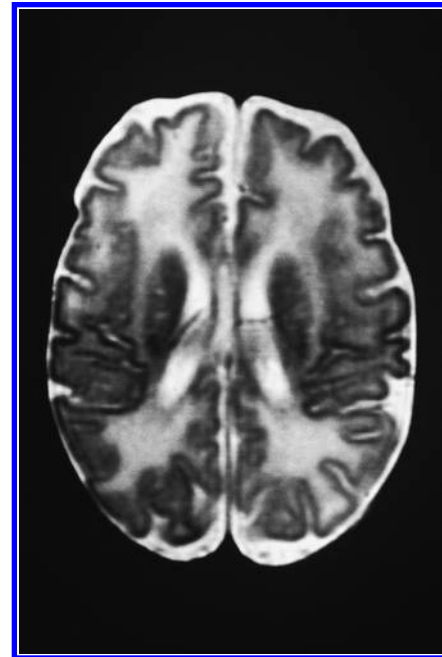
Magnetic resonance image of the head of a 5-week-old infant with Cbl C disease. Abnormal signal was consistent with white matter disease. (Images were kindly supplied by Dr GM Enns of Stanford University.)
